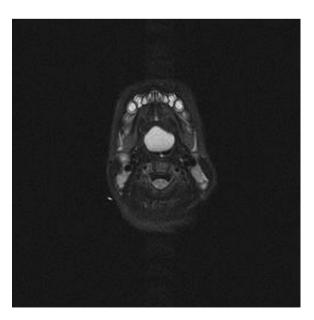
T2-weighted MNR showing a hyperintense lesion.
